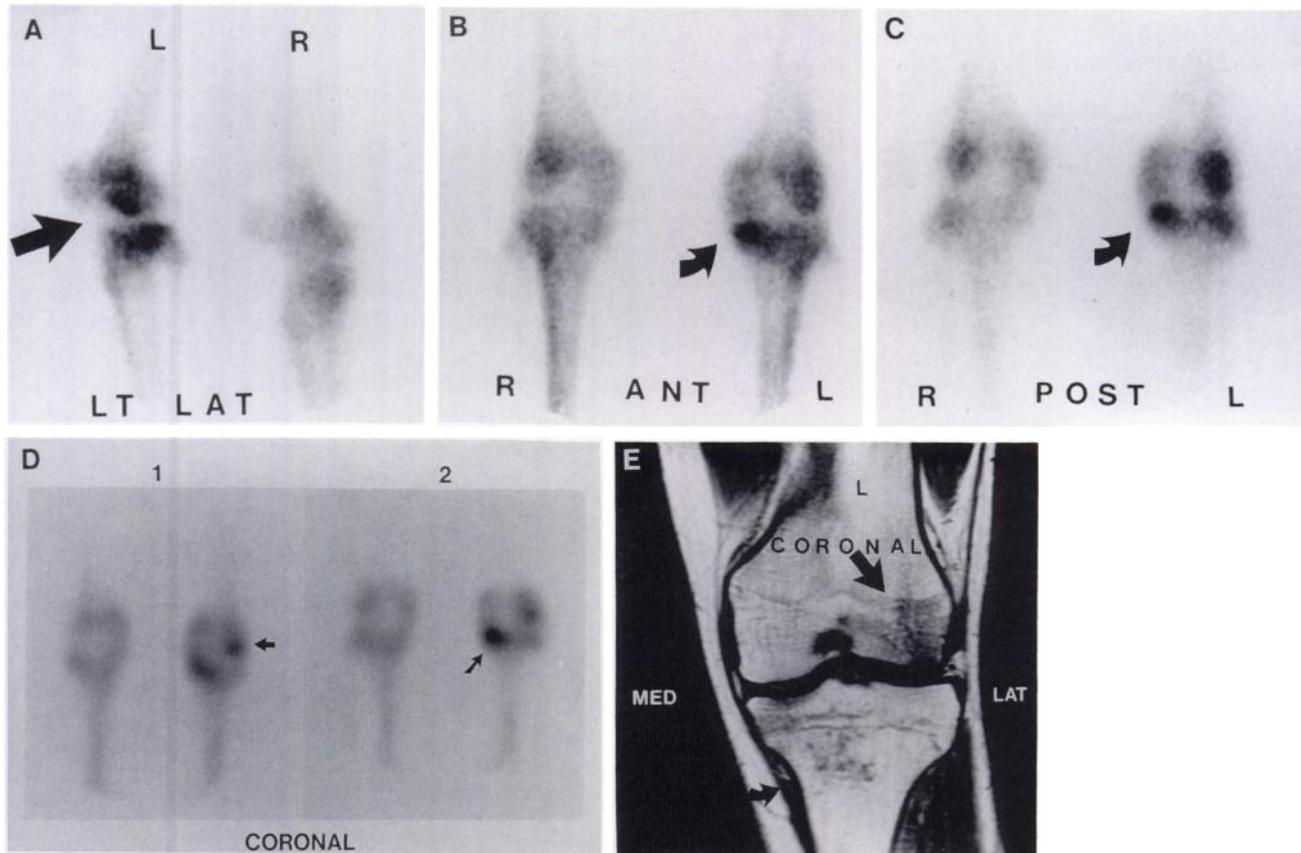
Patient 11. (A) Lateral bone scintigraphy demonstrates an obvious focal lesion in the subchondral bone in the weight-bearing region of the lateral femoral condyle (arrow). This is the only planar image that demonstrates the focal femoral lesion. (B) Anterior bone scintigraphy demonstrates an additional lesion in the left medial tibial plateau (curved arrow). There is diffuse periarticular increased uptake about the knee but no definite lateral femoral condyle lesion is identified in the anterior projection. (C) Posterior bone scintigraphy has been mirror-imaged to facilitate comparison. The medial tibial plateau lesion (curved arrow) has been again demonstrated along with diffuse increased periarticular uptake. The focal lateral femoral condyle lesion is not appreciated. (D) Coronal SPECT demonstrates the left lateral femoral condyle lesion on cut #1 (arrow) and the medial tibial plateau lesion on cut #2 (curved arrow). The SPECT image is probably easier to interpret. (E) Coronal MRI confirms the lateral femoral lesion (arrow) and the medial tibial plateau lesion (curved arrow).
